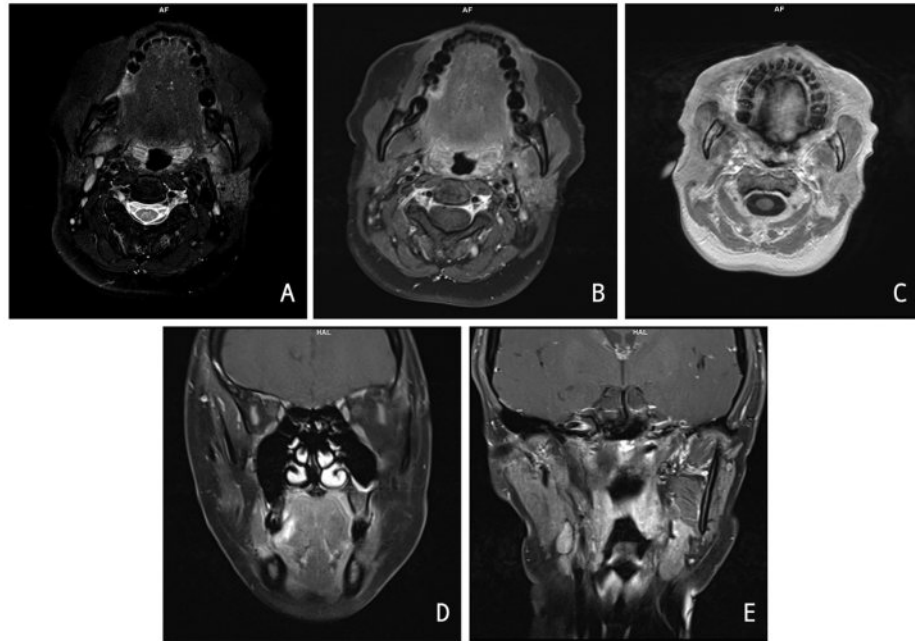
MRI of the head.
